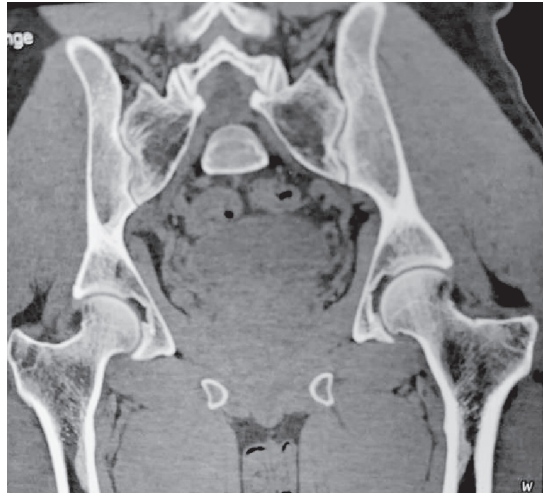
CT coronal of pelvis showing hip and sacroiliac joints
